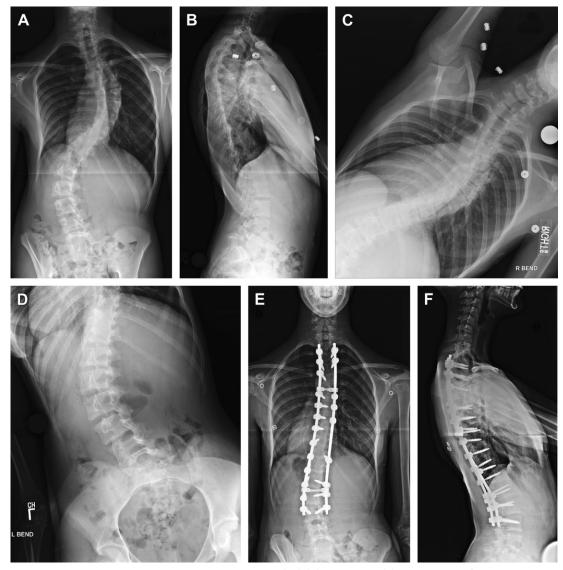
Lenke 3. Preoperative standing posteroanterior (PA) (A) and lateral (B) radiographs of a 12-year-old girl with a right 72° main thoracic curve and a left 56° lumbar curve. Right (C) and left (D) bend films show that the main thoracic curve bends down to 56°, and the lumbar curve bends down to 40°. Two-year follow-up PA (E) and lateral (F) radiographs show correction of the main thoracic curve to 16° and correction of the lumbar curve to 18° with posterior pedicle screws from T3 to L4.
